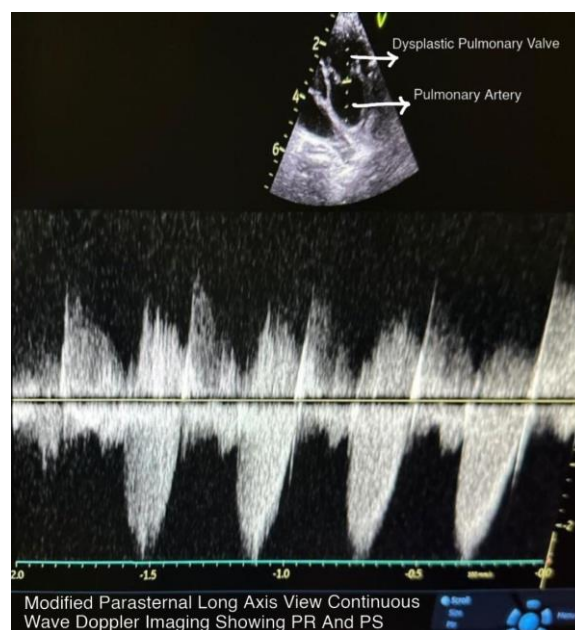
Modified parasternal long axis view continuous wave doppler imaging showing PR and PS
